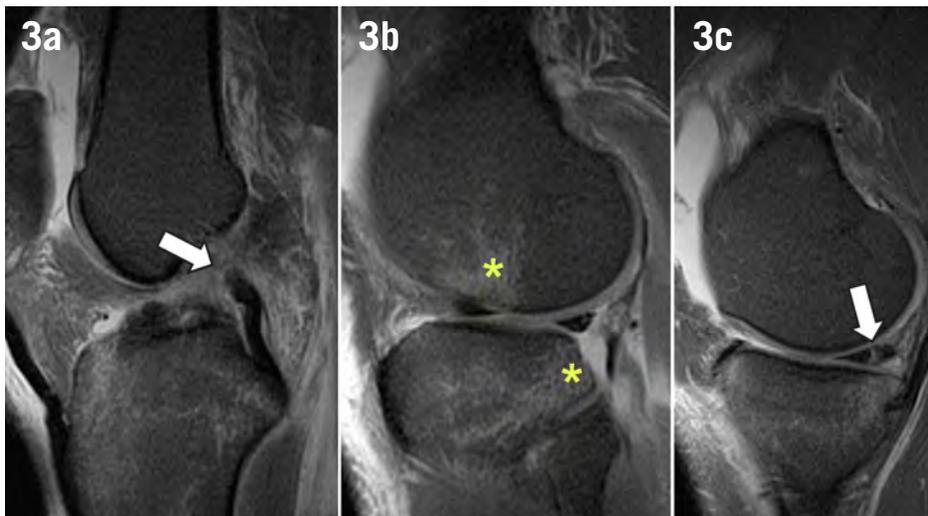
Magnetic resonance imaging of complete tear of the anterior cruciate ligament. Sagittal T2 weighted images with fat saturation from the intercondylar region (a), lateral compartment (b) and medial compartment (c) show complete discontinuity and absence of the ACL (arrow in a), the typical contusions in the lateral compartment (asterisks in b) and a vertical tear in the posterior horn of the medial meniscus (arrow in c).
